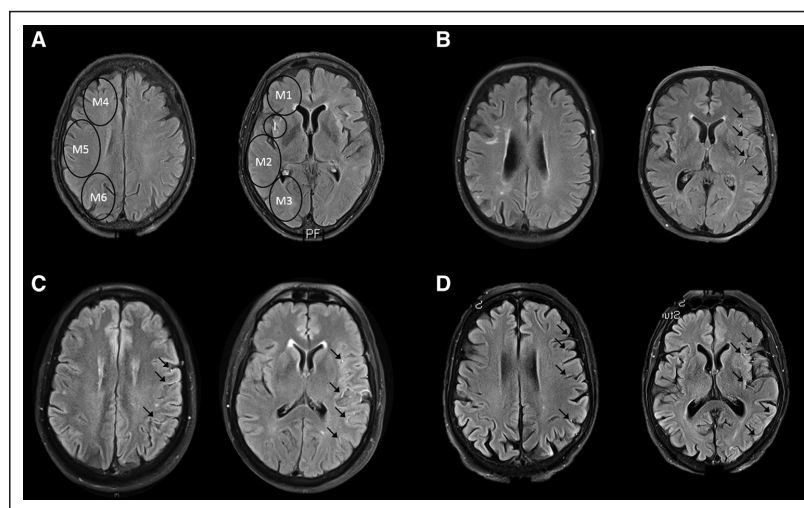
Examples of fluid-attenuated inversion recovery hyperintense vessel–Alberta Stroke Program Early CT Score (FHV-ASPECTS) ratings. FHVs were defined as linear or serpentine hyperintensities corresponding to a typical arterial course on at least 2 consecutive axial slices. FHV-ASPECTS score was evaluated on 2 standardized slices (A), together representing 7 vascular territories of the middle cerebral artery (M1–3 segments and the insular ribbon, and M4–6 segments). The detection of FHV (black arrows) in each middle cerebral artery–ASPECTS territory was added up and the sum then subtracted from 7. Panels represent different rating examples: (A) no FHV visible; FHV-ASPECTS=7. B, FHV visible in M1, M2, and I; FHV-ASPECTS=4. C, FHV visible in M2, M3, M5, M6, and I; FHV-ASPECTS=2. D, FHV visible in all territories; FHV-ASPECTS=0.
